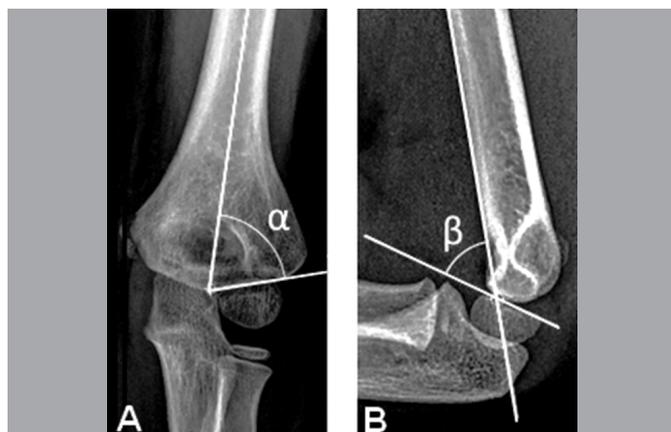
Radiographic parameters used for evaluation of elbows. A: The Baumann angle is formed by the intersection between the longitudinal line of the humerus and a line tangential to the growth plate of the capitellum; B: The humeral capitellar angle is formed by a line tangential to the anterior surface of the humerus and another line tangential to the growth plate of the capitellum.
